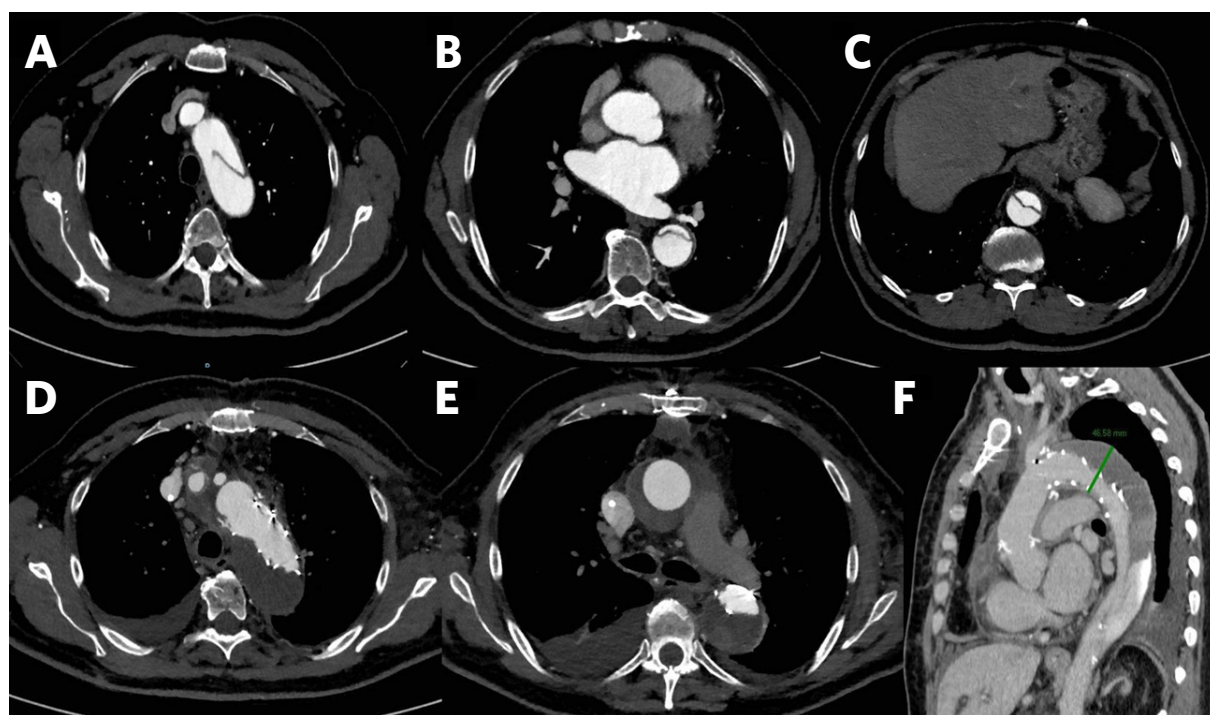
Frozen elephant trunk procedure with Thoraflex hybrid prosthesis in a case of acute type B aortic dissection. Pre-operative computed tomography (CT)-angiogram shows the entry tear downstream of the left subclavian artery and the dissected descending thoracic and thoracoabdominal aorta (A, B, C); two years-follow up CT-angiogram shows the complete peri-stent false lumen thrombosis (D, E, F)
